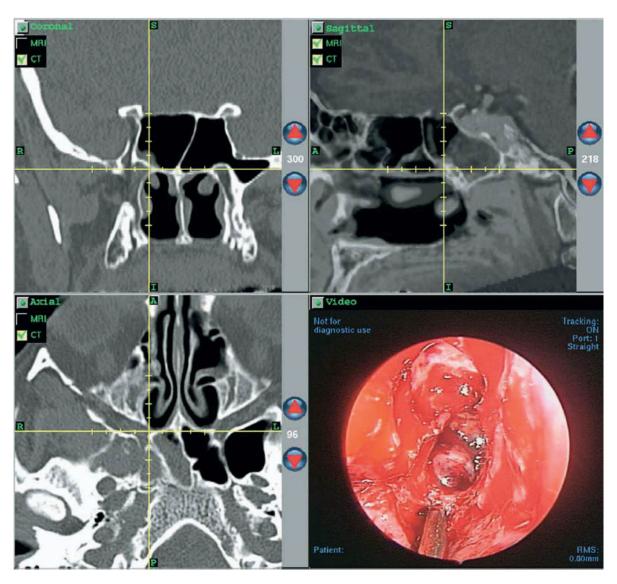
This intraoperative image capture was obtained during computer-aided endoscopic repair of large sphenoid encephalocele. *Left panels*: conventional CT images. *Upper right panel*: fused CT-MR image. The sagittal image shows the encephalocele filling much of the sphenoid sinus. Intraoperatively, navigation with the CT-MR fusion images facilitated complete resection of the encephalocele as well as complete definition of the skull base defect. From: Leong JL, Otolaryngol Head Neck Surg 2006; 134:868–876
